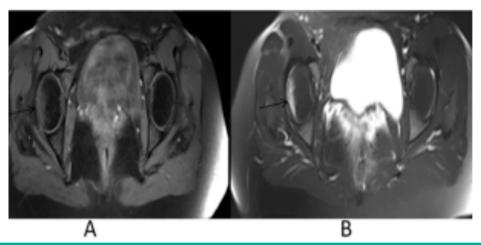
Magnetic resonance imaging, A. Hypotenseedema in T1A, B. In the T2A, the right femur head is laterally hyperintense in the subcortical area
